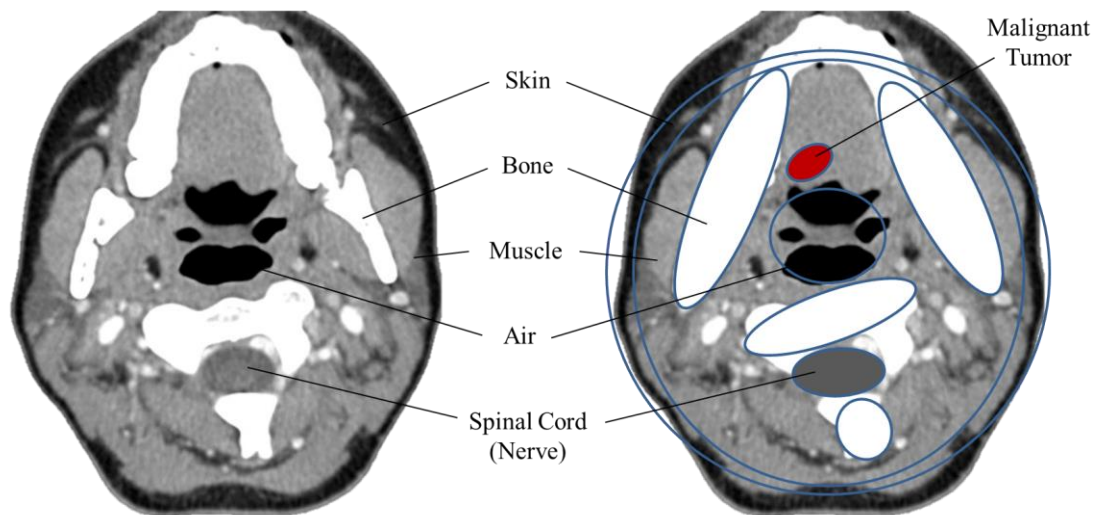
Simplified permittivity map from a normal CT of the neck
